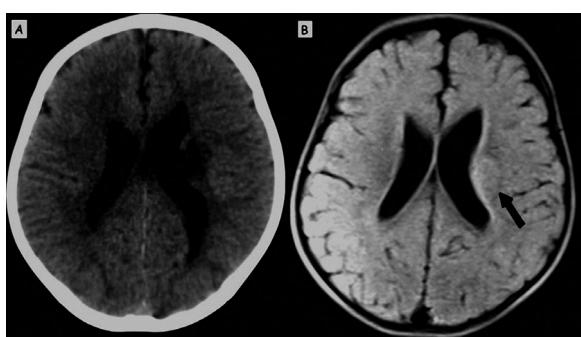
Hypodense lesion in the periventricular deep white matter next to the corpus of the left lateral ventricle in cranial computerized tomography (A); and hyperintense lesion (black arrow) in the periventricular deep white matter adjacent to the left lateral ventricle on axial fluid attenuated inversion recovery magnetic resonance imaging (B).
